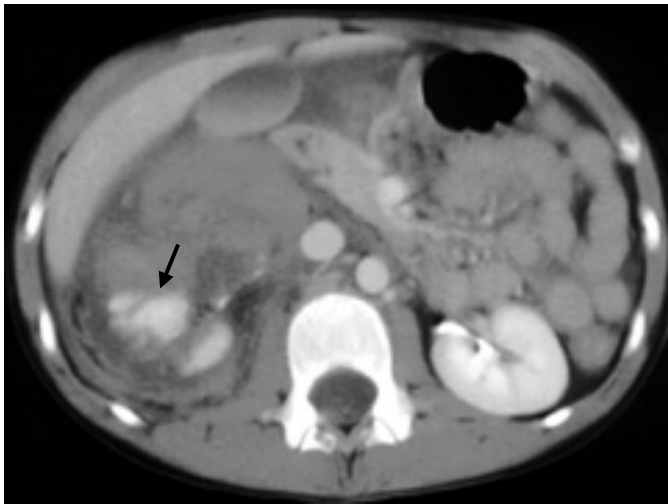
Axial contrast-enhanced CT section shows a large haematoma surrounding the fractured lower pole of the right kidney (arrow). Renal trauma [99]
